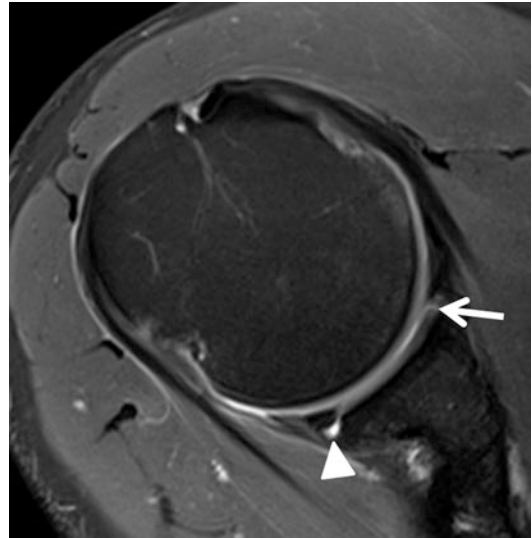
Labral tear on indirect MR arthrography. Axial T1-weighted fat-suppressed image from an indirect MR arthrogram demonstrates slightly increased signal at the base of the anterior labrum, suggestive of tear (arrow). Without distension of the joint, it is unclear if this is indicative of a stable, healing tear with enhancing granulation tissue within the cleft versus an unstable lesion. Note that there is also linear enhancement at the base of the posterior labrum reflecting tear in this patient (arrowhead)
